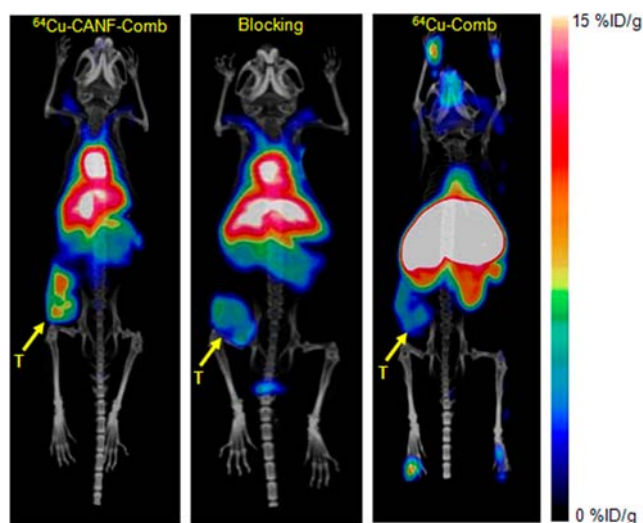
PET/CT images of ^{64}Cu -CANF-Comb, ^{64}Cu -CANF-Comb blocking, and ^{64}Cu -Comb in CWR 22 tumor at 24 h post injection. T: tumor.
